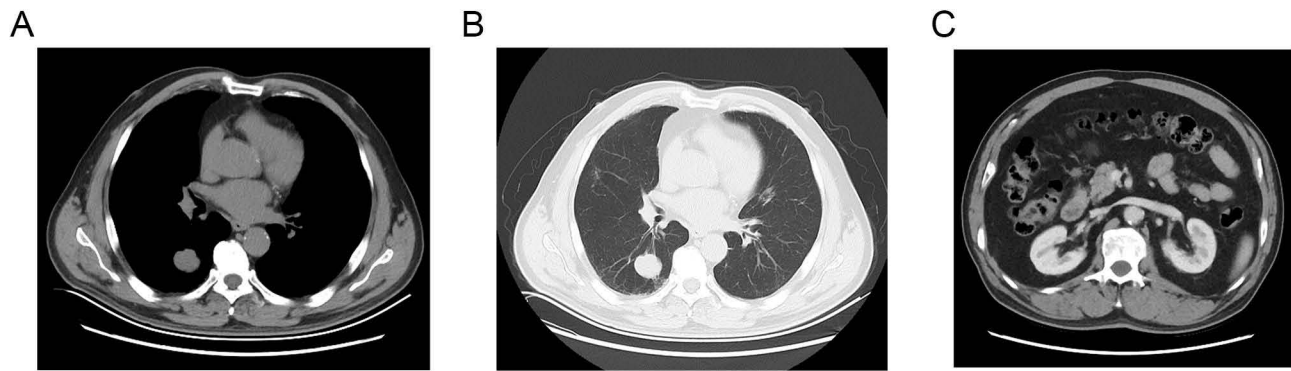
Chest and abdominal CT scan results prior to the patient's last hospitalization (March 25, 2025). (A) The patient's chest CT mediastinal window reveals multiple solid nodules in both lungs. The largest nodule is located in the right lower lobe and remains stable compared to previous findings (2.9×2.6 cm). (B) Patient's chest CT image in lung window. (C) Abdominal CT scan reveals thickening of the greater curvature of the stomach and thickening of the gastric fundus, with perigastric lymph nodes showing reduced size compared to previous findings (1.1×1.4 cm).
